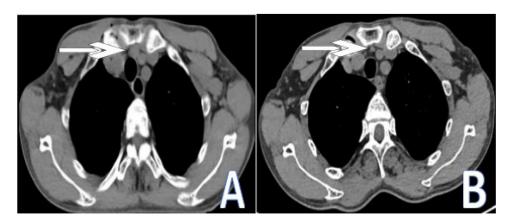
Comparison of size changes of parathyroid nodules before and after ablation on chest CT of ectopic hyperplasia. The size of the preablation nodules was about $17 \times 12 \times 14 \text{ mm}$ (A). The size of the nodules after ablation was about $6 \times 4 \times 6 \text{ mm}$ (B).
